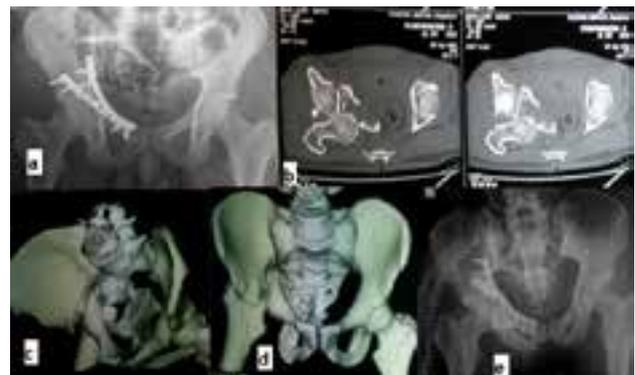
a) Preoperative radiograph, b) axial CT image, c and d) preoperative 3D CT, a) Post-operative radiograph after fixation using Kocher-Langenbeck followed by modified Stoppa approach in a 30-year-old male patient with transverse fracture and comminution of quadrilateral plate.
